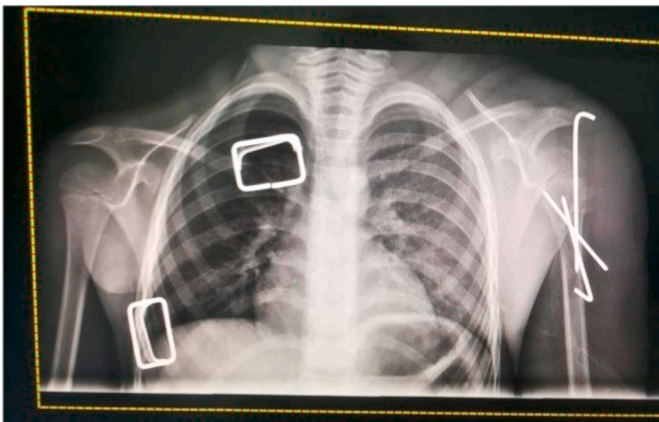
Immediate Anteriorposterior radiograph of bilateral shoulders demonstrating, fracture dislocation reduction & fixation with 3 k-wires.
